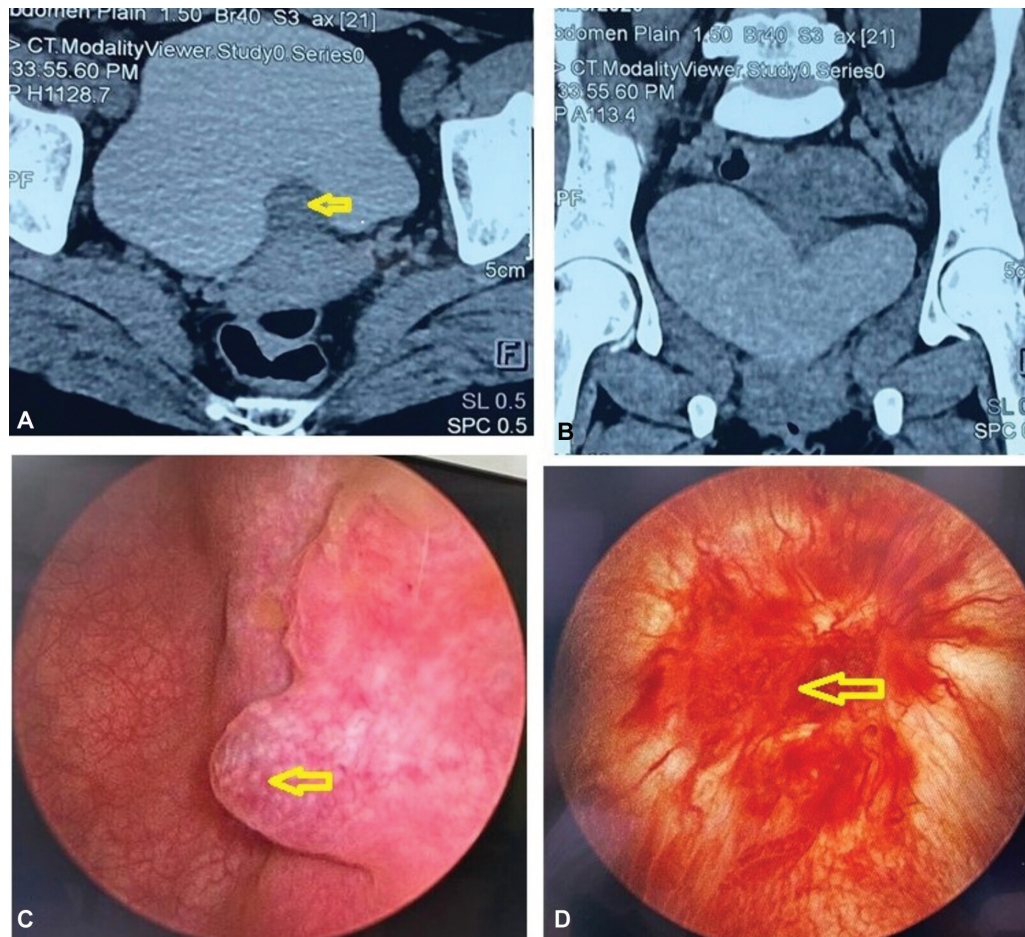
(A and B) Contrast-enhanced computed tomography scan showing a mass arising from the posterior wall of urinary bladder. (C) Cystoscopy shows a solid mass in the posterior wall of urinary bladder. (D) Recurrent lesion at 3 months after transurethral resection of bladder tumor.
